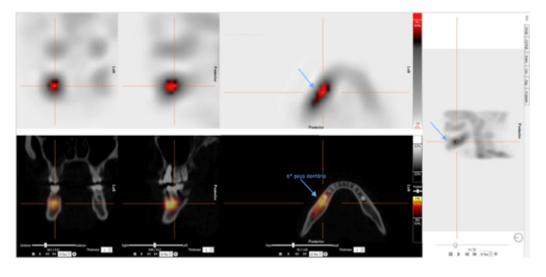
Bone scintigraphy
